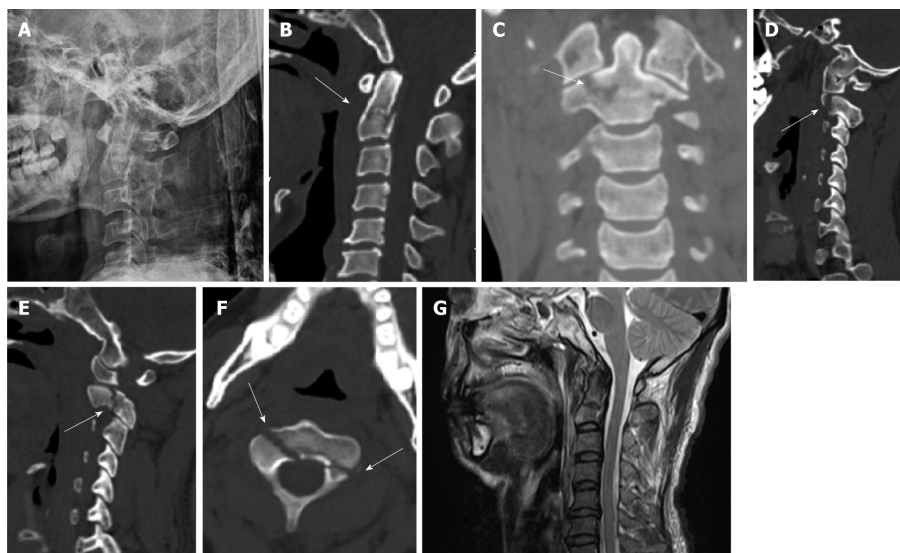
Imaging examinations were performed before surgery. A-F: Plain radiographs and computed tomography scan showed a C2 fracture consisting of an odontoid Type III fracture associated with a Hangman fracture categorized as a Levine-Edwards Type I fracture (no translation and angular deformity); G: Magnetic resonance imaging indicated no spinal cord injury, edema or hemorrhage. There was no obvious damage to the transverse ligament of the atlas and the C2-3 intervertebral disc.
